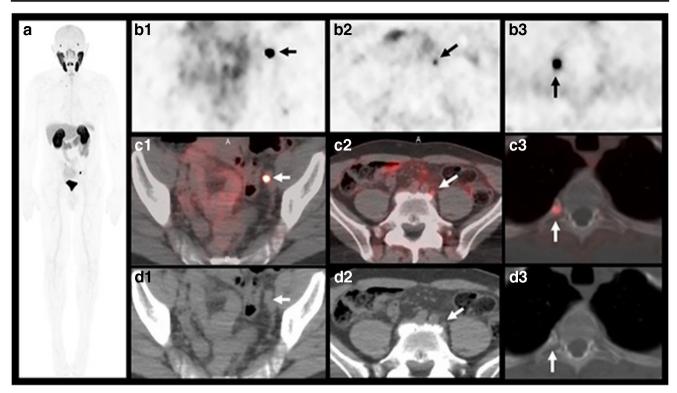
Sixty-four-year-old male with rising PSA (1.42 ng/mL) after 8 years post-prostatectomy for prostate cancer, Gleason 7 (4+3), T3aNoMx. Maximal intensity projection (A), axial PET (B1, B2, B3), axial fused PET/CT (C1, C2, C3), and axial CT (D1, D2, D3) images
